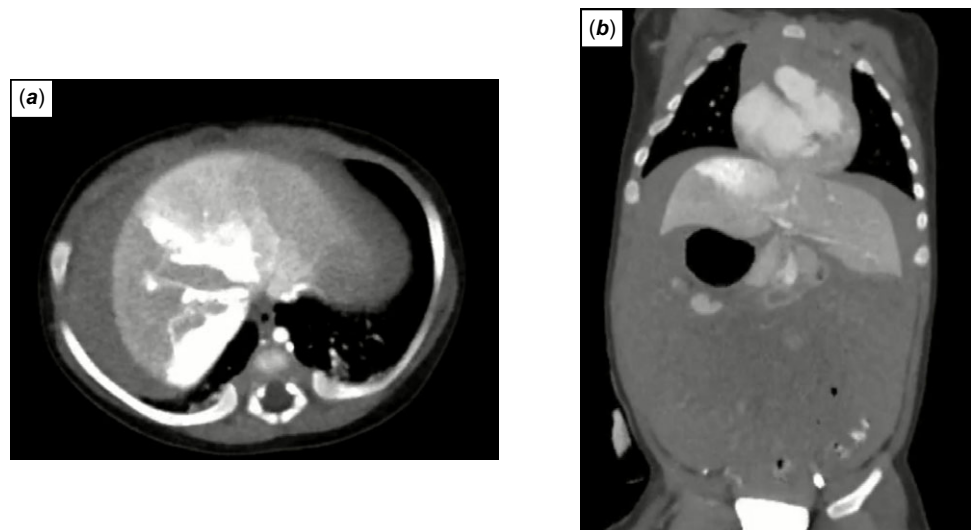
Axial (a) and coronal (b) views of contrast-enhanced CT. Hepatic injury with intra-hepatic extravasation and massive ascites were observed.
